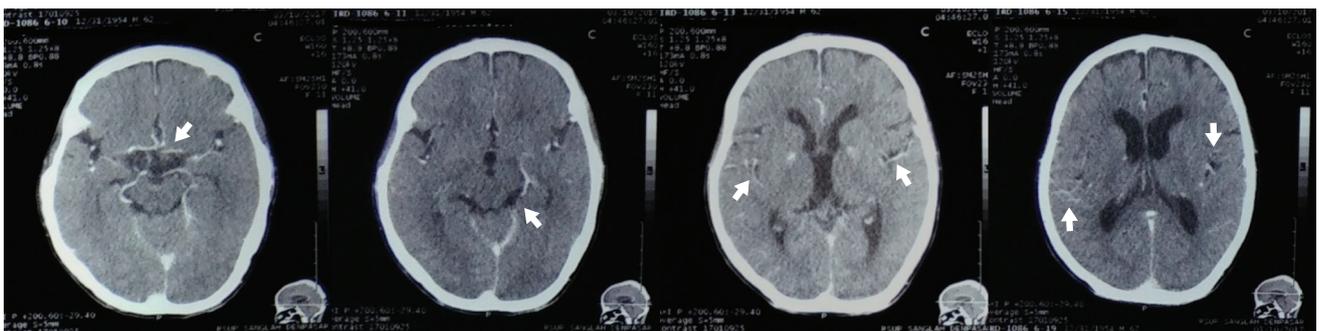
Contrast-enhanced brain computed tomography (CT) scan demonstrated leptomeningeal enhancement (white arrows)
